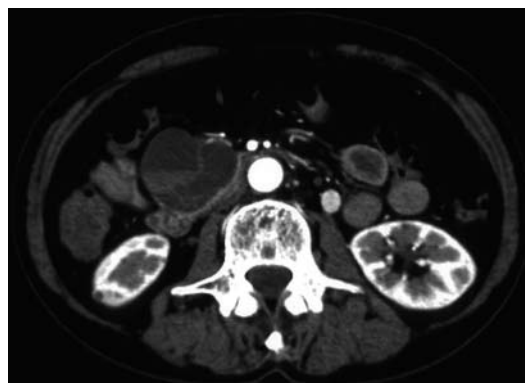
Contrast-enhanced computed tomography scan obtained in the arterial phase showing a multilocular cystic mass in the uncinate process of the pancreas. No pancreatic ductal dilatation or invasion into adjacent arteries or portal vein are identified.
